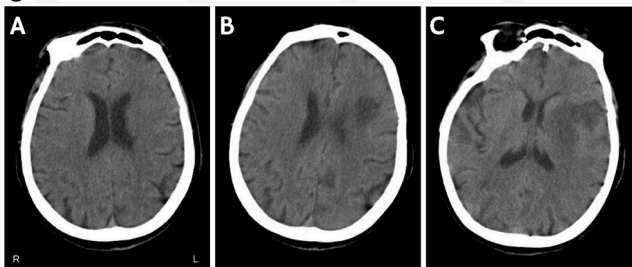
Axial Cranial Computed Tomography (CT) scan showing the evolution of an ischemic insult area. A: Initial CT scan at admission, with no evidence of ischemic injury. B and C: Follow-up CT scans seven days later, revealing a poorly defined hypodense lesion in the external lenticulocapsular region and the left frontal lobe.
